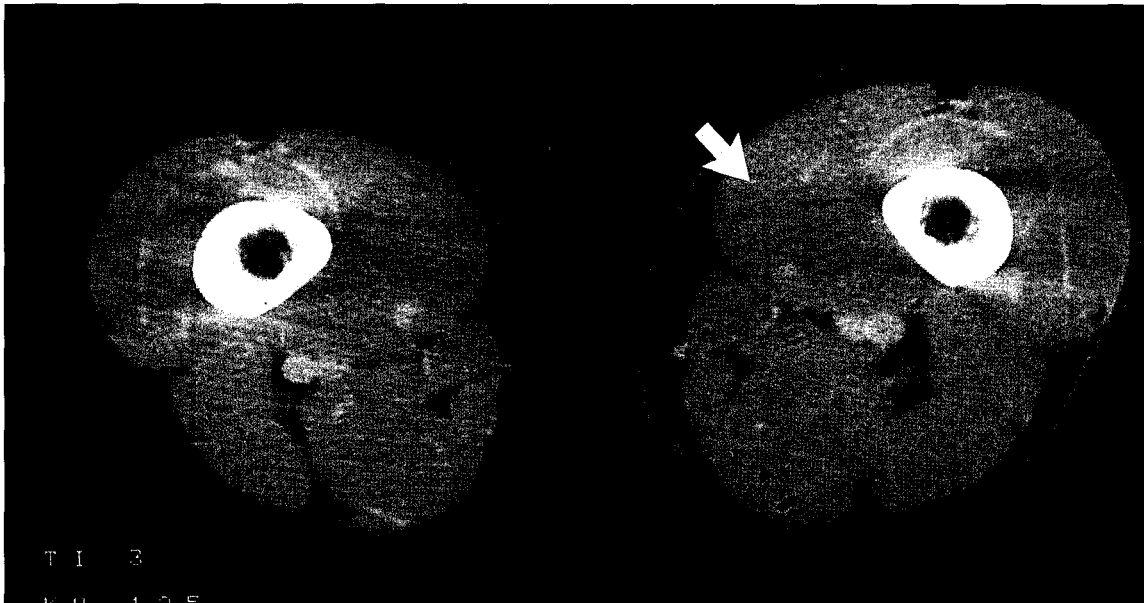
CT scan of the thighs with left femoral thrombosis. Enlargement of the left muscle compartment (large solid arrow).
